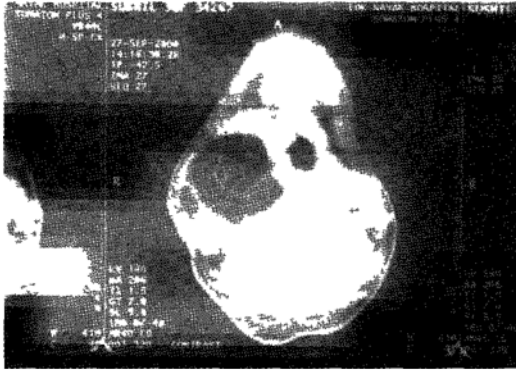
Fig II CT Scan- axial cut
